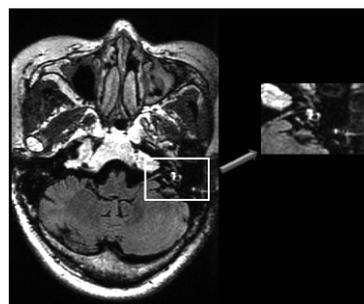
3D-FLAIR magnetic resonance image of the left ear of a 63-year-old woman with ISSNHL in the axial plane. The image was taken 24 h after intratympanic injection of Gd. The white rectangle demonstrates our region of interest. Gd is clearly demonstrated in the vestibule and semicircular canals in this image.
